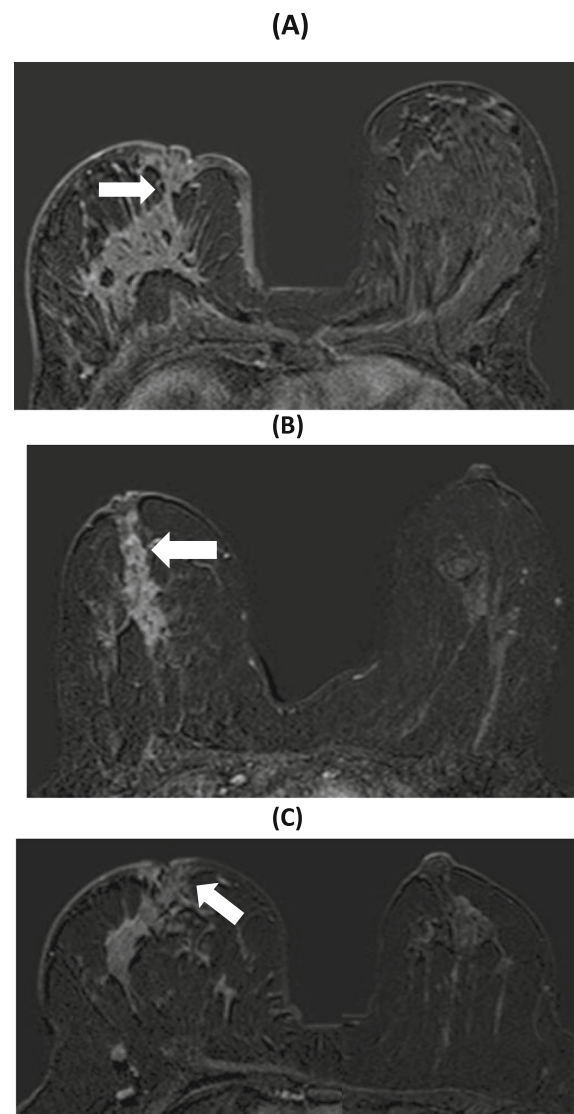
Cases with pathologically proven malignant nipple infiltration. a Axial early subtraction MR image shows irregularly shaped heterogeneously enhancing mass with speculated margins in the retroareolar region of the right breast, the nipple appears retracted with abnormal unilateral nipple enhancement, and there is thickening in the periareolar skin with evidence of tumor nipple enhancement (linear non-mass enhancement extending from the mass to the nipple base) (arrow). Pathological diagnosis revealed stage IIIC; grade II IDC with nipple infiltration; ER and PR: negative; and HER2: positive and high ki67. b Axial early subtraction MR image shows heterogeneous linear non-mass enhancement seen in the retroareolar region of the right breast (arrow). The right nipple appears retracted with the linear non-mass enhancement continuous with the nipple base. No periareolar skin thickening. No abnormal unilateral nipple enhancement. Pathological diagnosis revealed grade II IDC with nipple infiltration, ER: positive, PR: positive, and HER2: positive with high ki67. c Axial early subtraction MR image shows heterogeneous segmental non-mass enhancement is seen in the retroareolar region of the right breast (arrow). The right nipple appeared retracted showing abnormal unilateral nipple enhancement with thickening in the periareolar skin. The non-mass enhancement is seen continuously with the nipple base. Pathological diagnosis revealed grade II IDC with malignant nipple infiltration, ER: negative, PR: negative, and HER2: positive with high ki67
